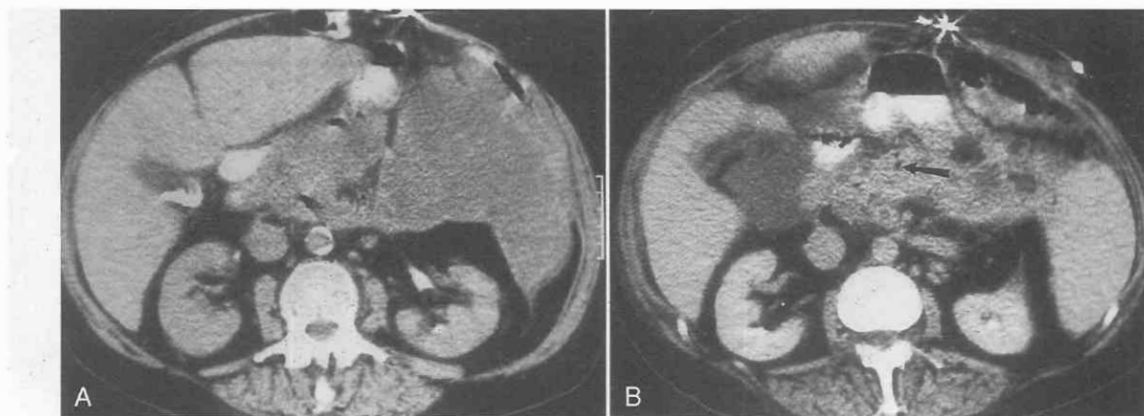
A, CT scan showing a large fluid collection in the left side of abdomen after rupture of a pseudocyst. B, Scan showing small gas bubble (*arrow*) within fluid collection in the pancreatic bed; aspiration subsequently showed this area to be infected.
